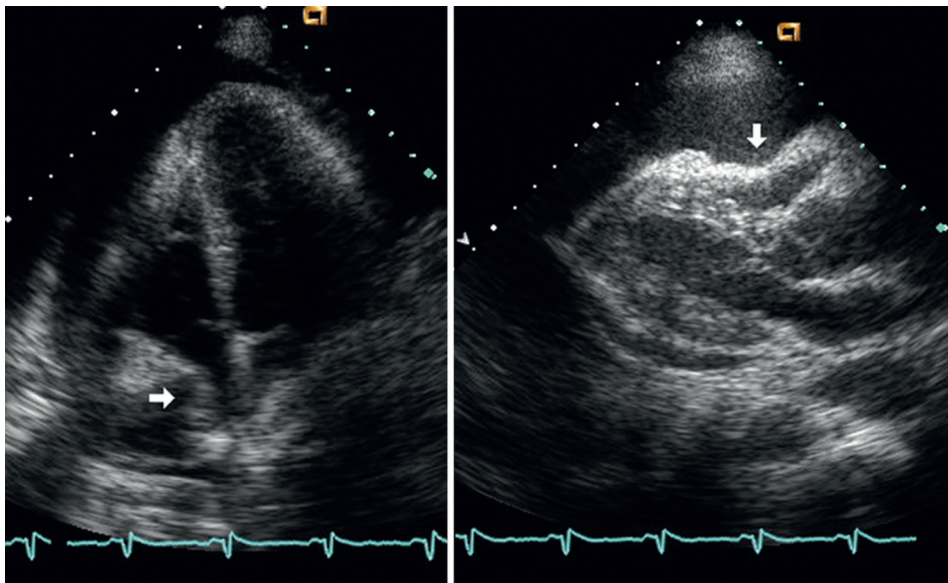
Signs of cardiac tamponade. Left, Apical four-chamber view showing RA inversion (arrow), a marker of tamponade. In this case, inversion, which is initiated in late ventricular diastole, has persisted well into ventricular systole. Right, Parasternal long-axis view showing RV collapse in diastole (arrow).
